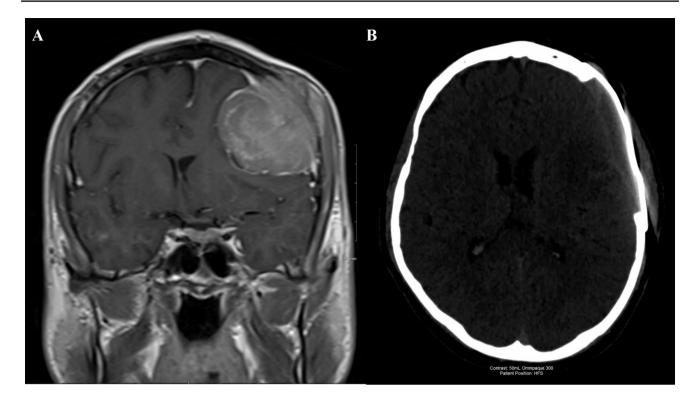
A A coronal MRI slice showing the presence of a large convexity meningioma with osseous involvement. B A post-operative scan showed a satisfactory placement of the titanium cranioplasty
